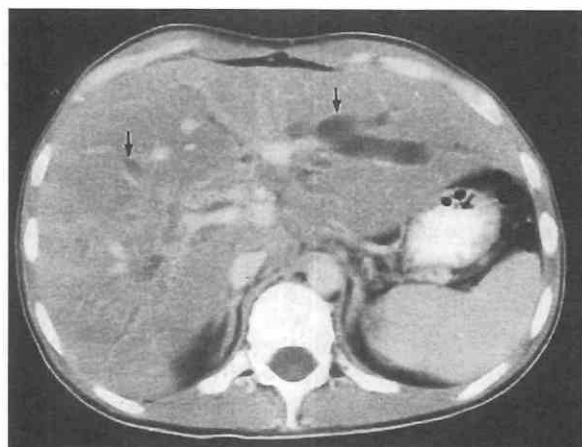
AIDS cholangitis with dilated intrahepatic ducts (arrows). Note asymmetry of dilatation with greater dilatation of the left ducts. (From Dolmatch BL, Laing FC, Federle MP, et al: AIDS-related cholangitis: radiographic findings in nine patients. *Radiology* 163:313, 1987.)
